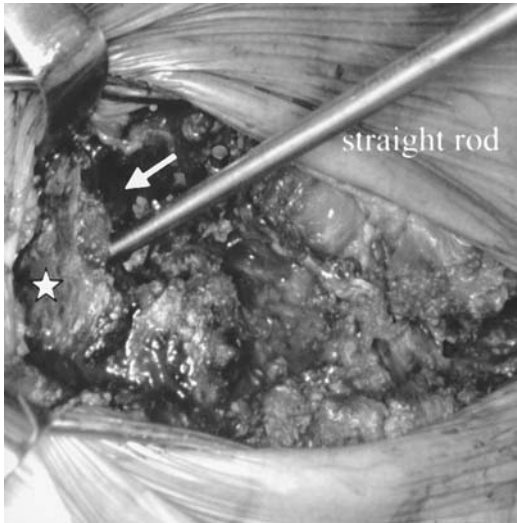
Iliac rod insertion. A block bone measuring approximately 2×2 cm is excised from the rod insertion point of the iliac crest to avoid skin irritation due to the rod. Prior to the rod insertion, an iliac probe should be inserted between inner and outer cortex of the ilium (asterisk) about 30 degrees caudally to the coronal plane of the pelvis. Straight iliac rod is inserted tentatively to confirm the direction and the length under control of anteroposterior x-ray image intensifier.
